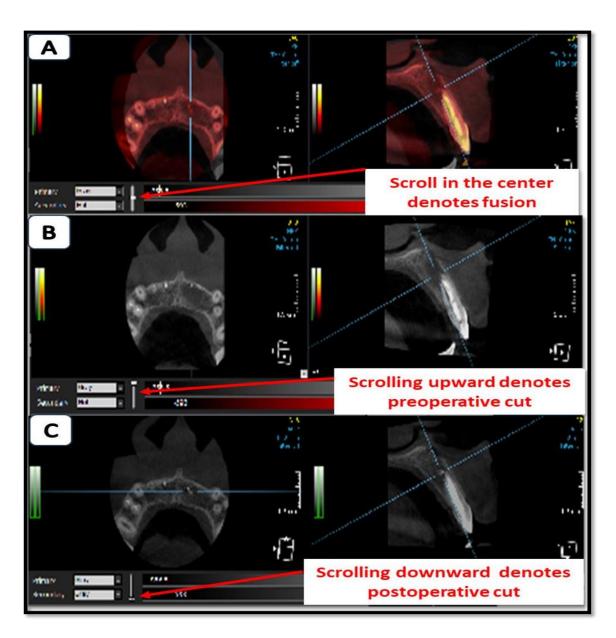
In the fused image; scrolling between pre- and post-operative images to reveal the same level of cut (A) Fused CBCT view. (B) scrolling upward to show Pre-operative CBCT view at certain cut. (C) scrolling downward to show Post-operative CBCT view at the same level of cut of pre-operative one.
